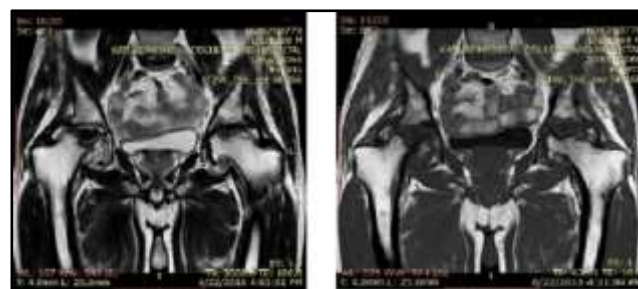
MRI T1W Coronal Sections showing Hypointense Signal in Bilateral Femoral Heads (Right > Left) with Flattening of Femoral Heads, Occasional Sclerosis and Cyst Formation. Bilateral Joint Spaces appears Obliterated in Patient with Avascular Necrosis of Hip
